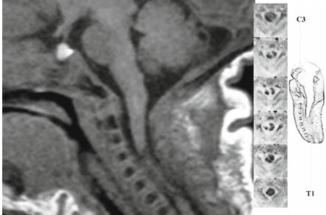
Term boy with quadriparesis from birth (hyperextended breech for which elective cesarean) deceased due to respiratory insufficiency in early infancy. MRI (sagittal T1 with assorted T2 axial scans at different cervical levels) pointed to a lesion from C3 to T1 that divided the cervical cord into a smaller right and larger left portion
